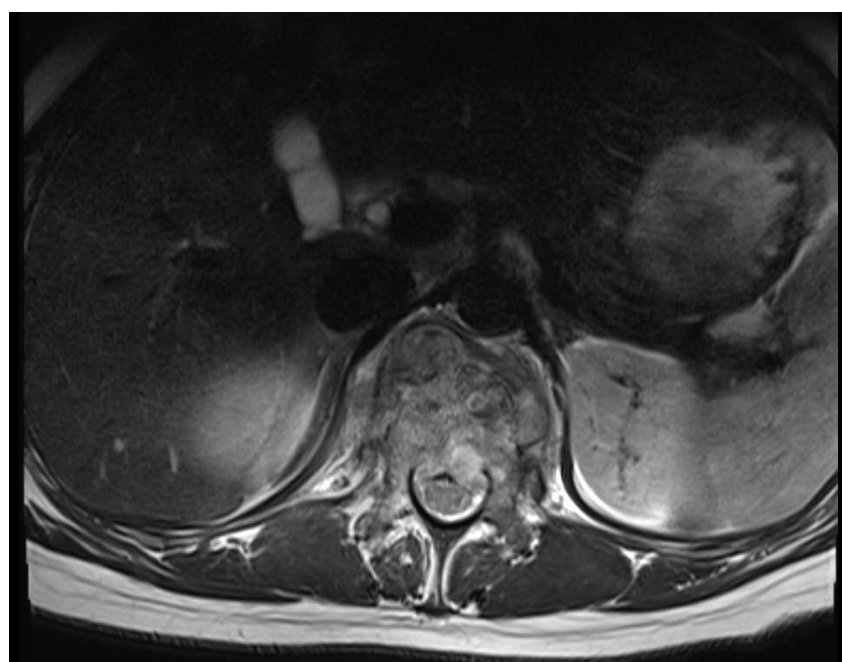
(Left): An MRI showing extensive bone destruction due to tuberculosis osteomyelitis.
